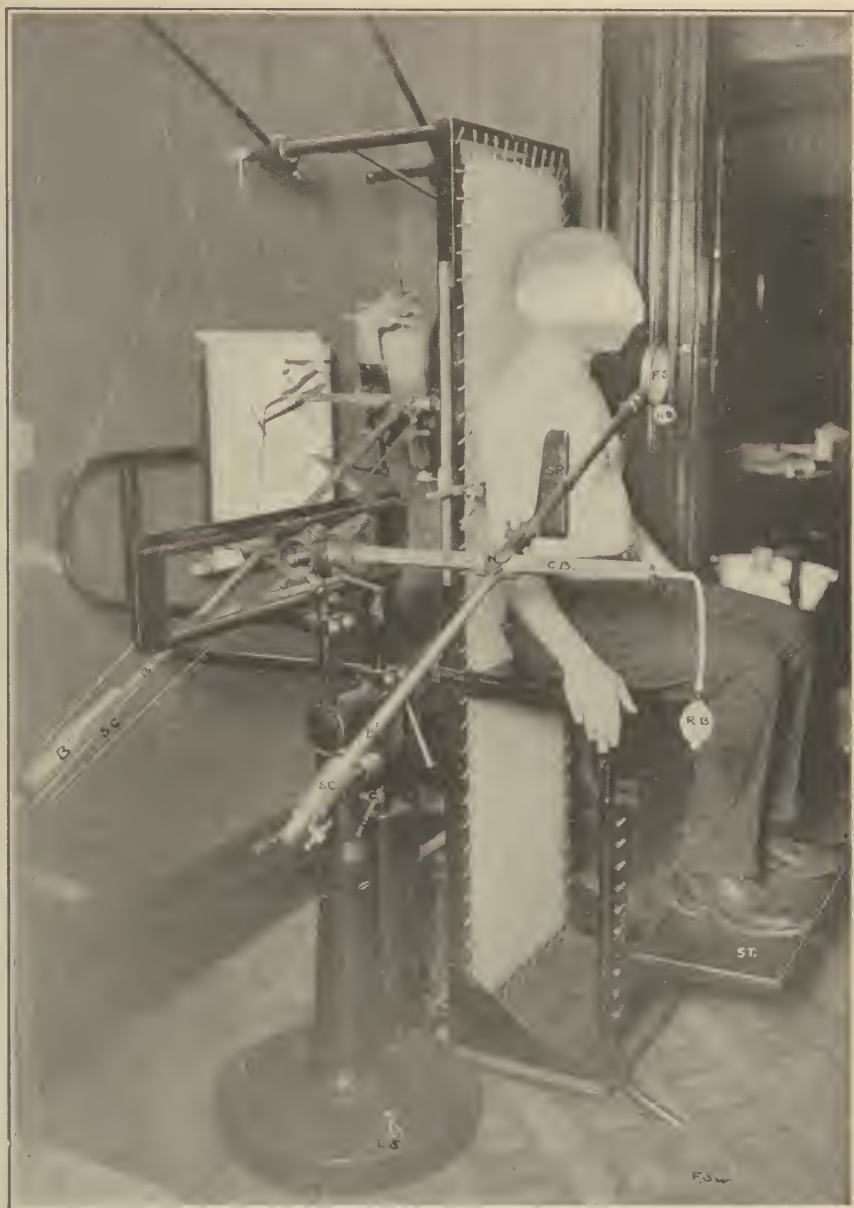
Groedel orthodiascope, front view. The patient sits with his feet resting comfortably on the adjustable step (ST); the side plates (SP) can be lowered or raised and pushed in or out; they are placed so that they fit snugly in the axillæ and against the chest of the patient. The fluoroscopic screen (FS) is grasped by the finger of the right hand in a small ring (R). The bar B' carrying the screen is connected by the hollow bar (CB) with the bar B''; the latter carries the X-ray tube so that any motion imparted to the fluoroscopic screen by the observer moves the X-ray tube as well. By loosening the nut (N) the bar (B') may be slid along the crossbar, thus the screen may be placed at any convenient distance from the patients chest. RB, rubber bulb used for marking purposes; SC, sliding counterweights so that the screen and X-ray bars may be properly counterpoised; C, cranks used to place the table in the horizontal position if necessary; LS, levelling screws; FSW, the electrical foot switch.
